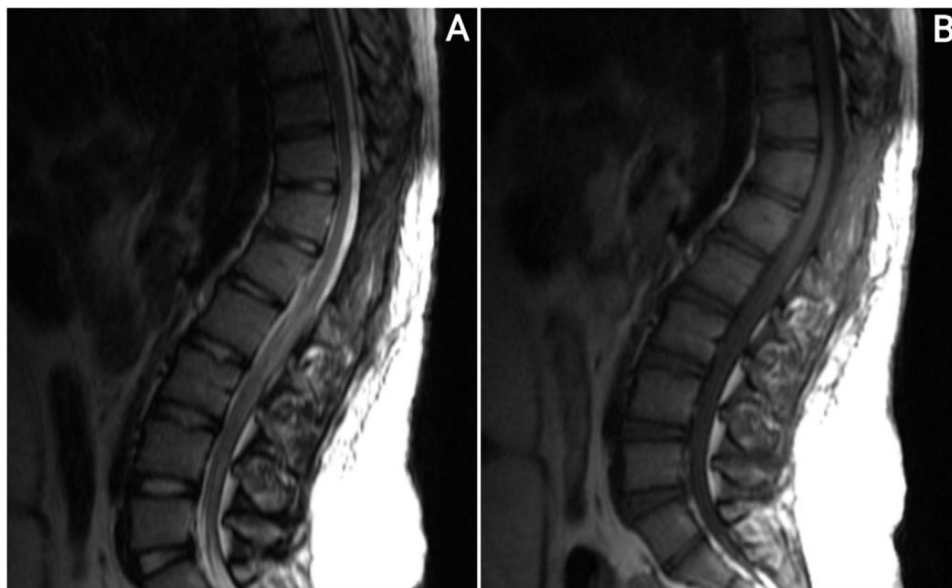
Contrast-enhanced magnetic resonance imaging (MRI) with gadolinium demonstrated a peripheral fluid signal surrounding the thoracic spinal cord, consistent with an epidural abscess from T9-T12 to L1, causing spinal cord compression. ([A] Sagittal section of T2-weighted sequence, [B] Sagittal section of STIR sequence, [C] Sagittal section of T1-weighted sequence).
